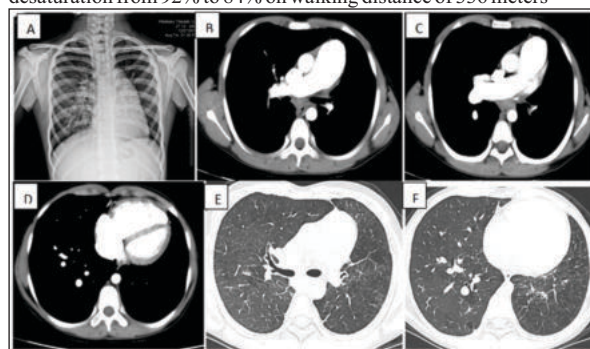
A- Chest X-ray showing left lung hyperlucency with decreased vascular markings; B, C, D- Axial sections of CTPA showing atresia of left pulmonary artery (LPA) with decreased broncho-vascular marking on left side; E, F- HRCT chest showing hyperlucent left lung along with decreased vascular markings and hyperinflation of right lung with herniation into left side
